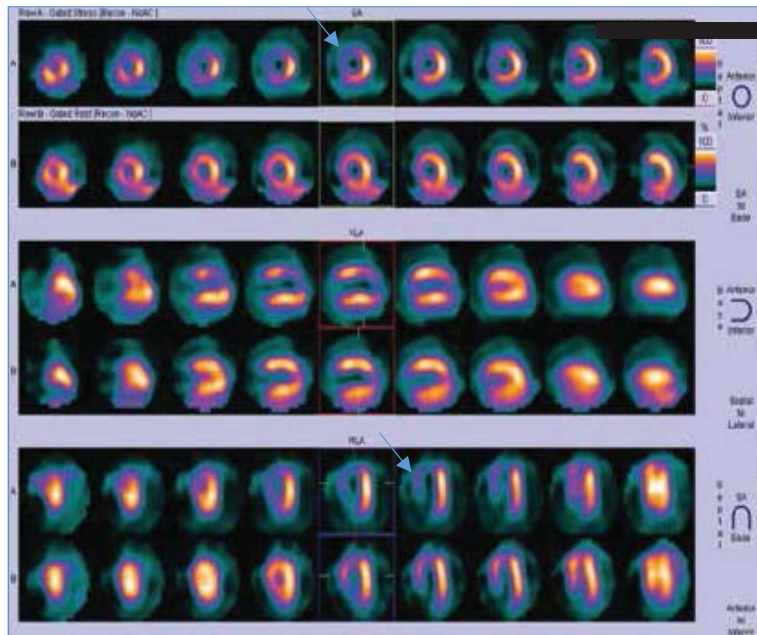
GMPI-SPECT Cardiac Stress image.
